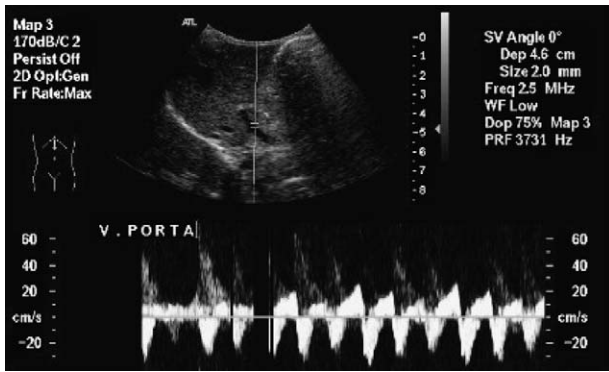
Ultrasound of the liver with the doppler in the main portal vein. The spectrum shows an arterialisation of the signal.
